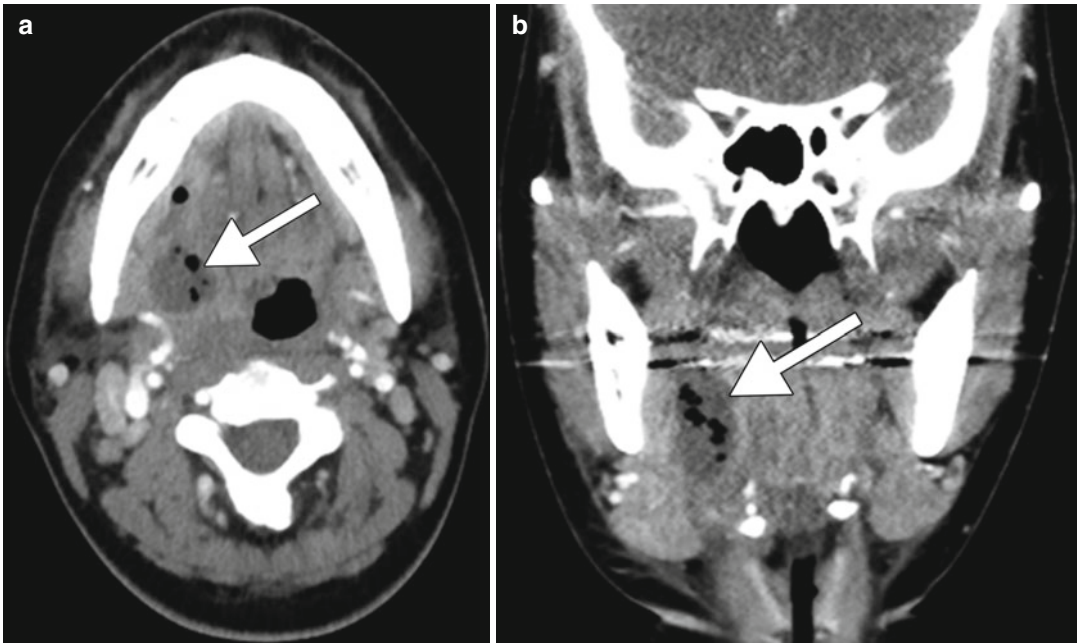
Floor of mouth abscess. Axial (a) and coronal (b) post-contrast CT images show a fluid collection with internal air in the right floor of the mouth (*arrows*) in a patient with mouth pain and fever
